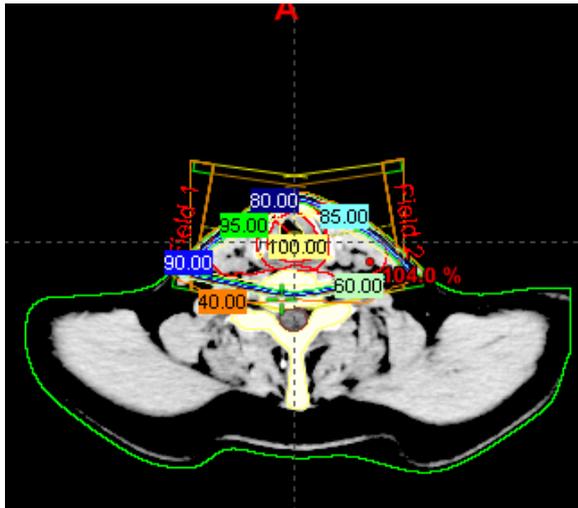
CT-scan with chart of isodoses
